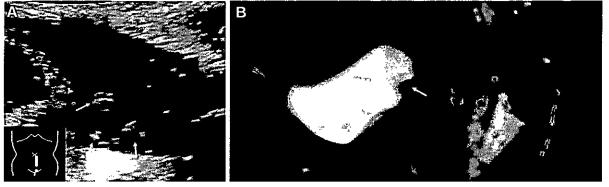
Bladder papillomatosis in a 7-year-old boy with Costello syndrome. (A) US image of the bladder shows multiple papillomas (arrows) in the bladder. (B) Sagittal T2-weighted fat-saturated MR image of the pelvis shows papillomas (arrow) along the posterior bladder wall.
